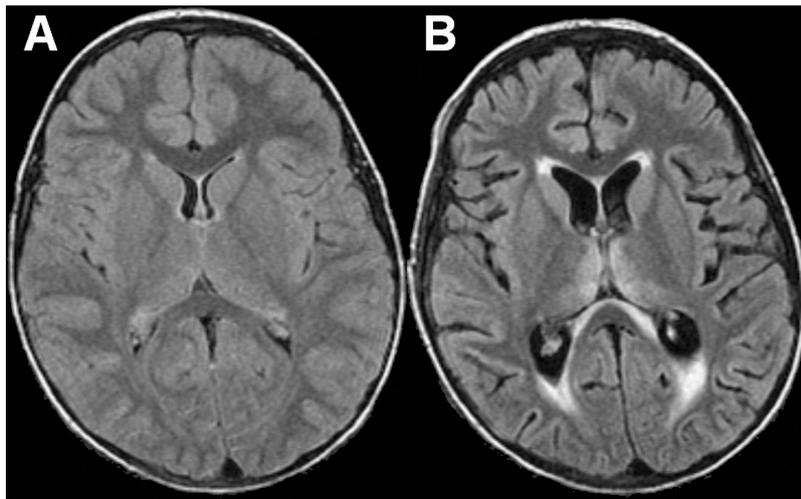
Magnetic resonance imaging. (A) Axial fluid attenuated inversion recovery image in a child with febrile infection-related epilepsy syndrome on day 1 of hospitalization shows no abnormalities. (B) Axial fluid attenuated inversion recovery image on day 30 of hospitalization shows widening of sulci and lateral ventricles suggestive of diffuse cerebral atrophy. Hyperintense signal changes are seen in bilateral thalami as well as along the ependymal margins of the ventricles and peri-atrial regions.
